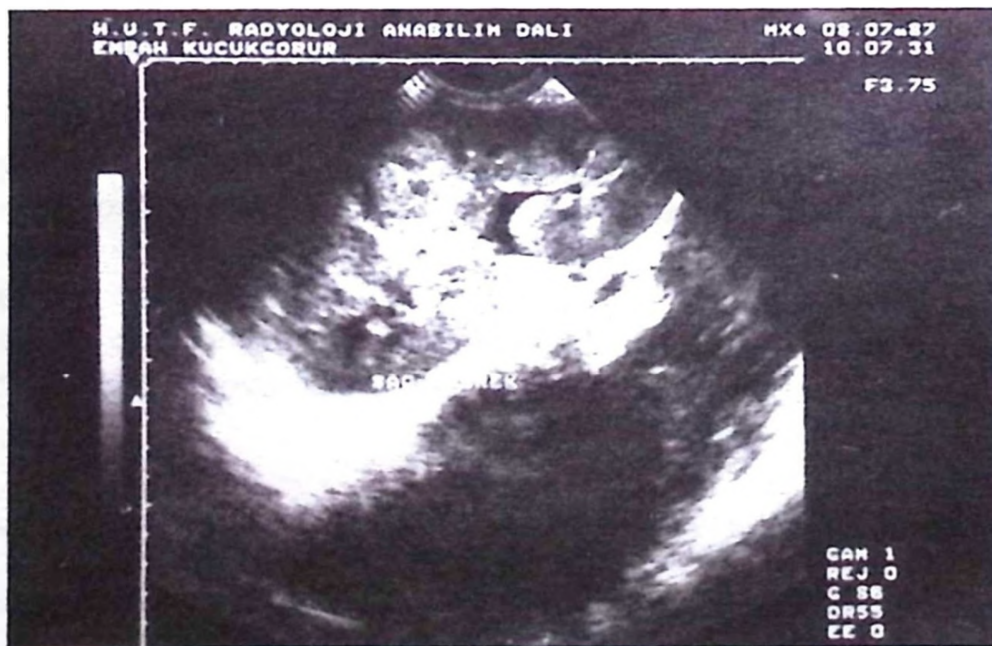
Ultrasonography showing an enlarged kidney with parenchymal thickening on the right side. There are several hypoechoic nodules and diffuse infiltration.
